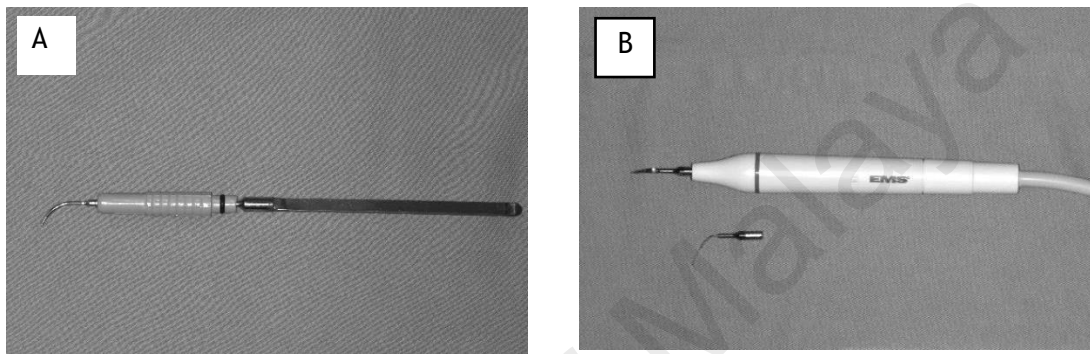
Ultrasonic scalers. (a) Magnetostrictive design (b) Piezoelectric design
